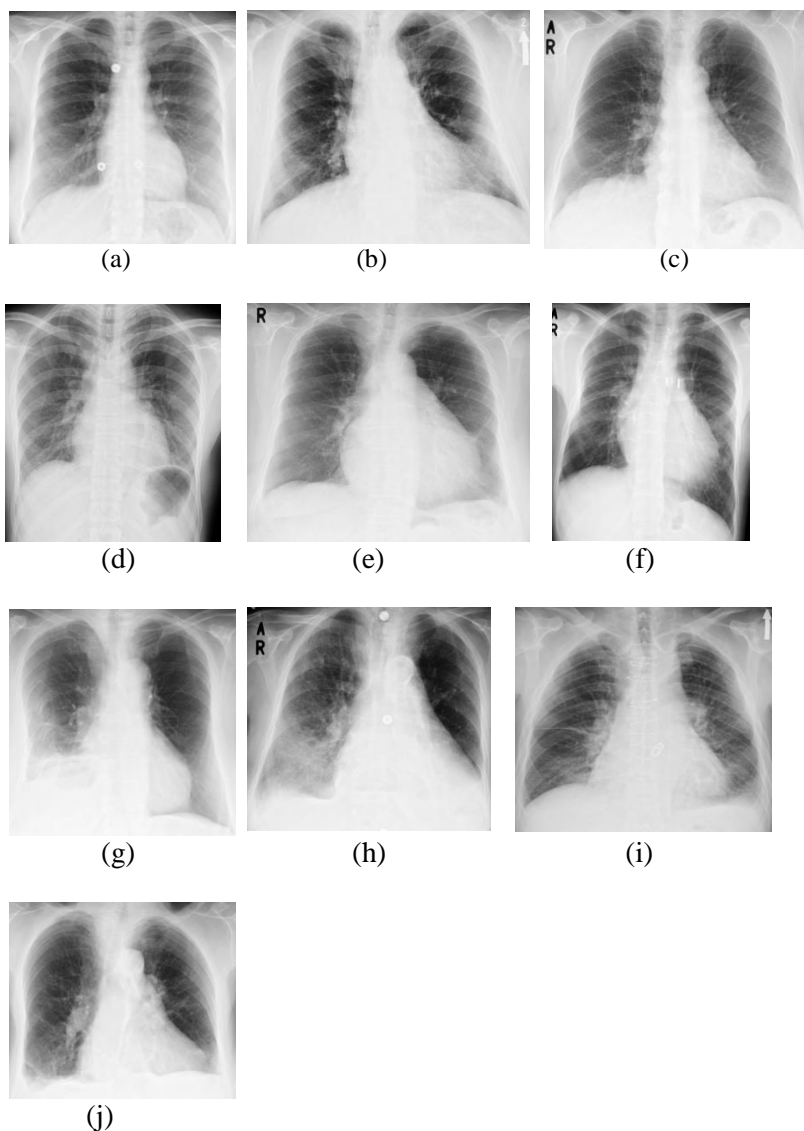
Chest x-rays categories examples: (a)-(c) healthy; (d)-(f) enlarged heart; (g)-(i) right effusion; (j) multiple pathologies: enlarged heart and right effusion.
